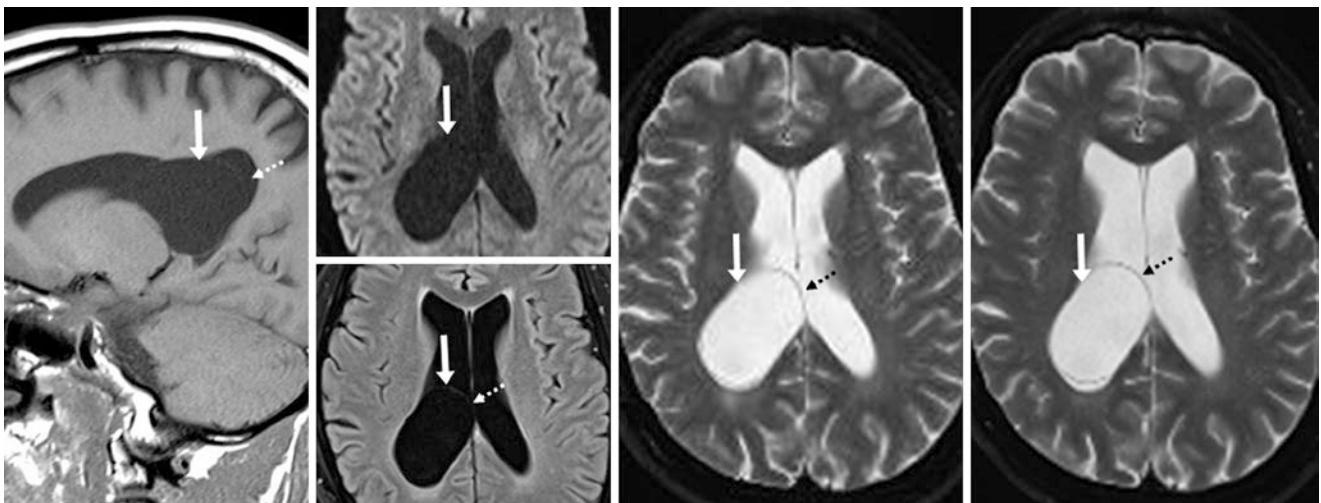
Comparison case of a large intraventricular cyst. A 54-year-old patient with headaches had a 4.5-cm cyst (arrows) of the right lateral ventricle without hydrocephalus on sagittal T1WI MRI (left), with a CSF-like signal on DWI/FLAIR (top and bottom, left middle). T2WI
